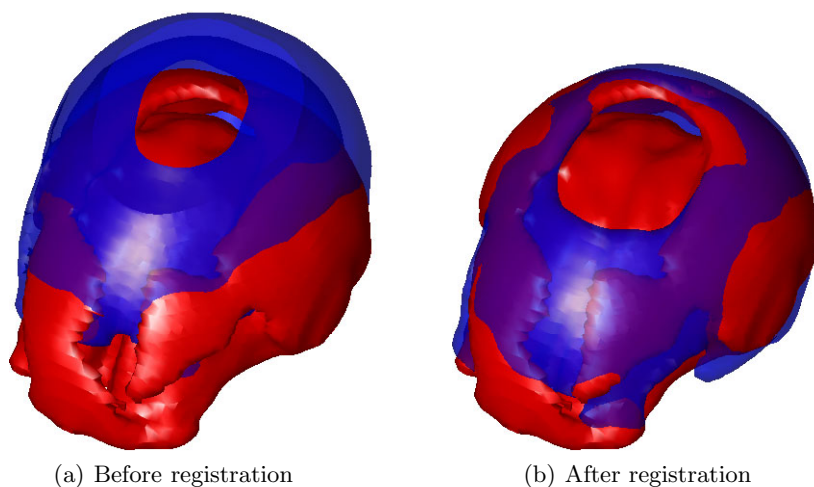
Isosurfaces of CT (blue) and MR-T1 (red) images of patient 4, before and after rigid registration
